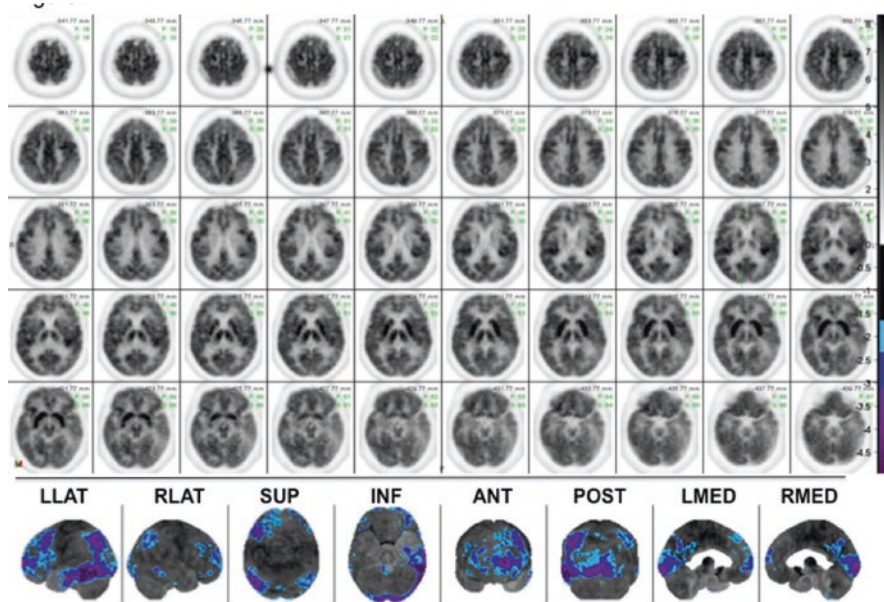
FDG PET scan showing serial axial images and surface-rendered z-score maps of significant hypometabolism relative to a normal control database showing selective mesial occipital hypometabolism in a patient with DLB. Additional temporoparietal and mild frontal association cortical hypometabolism is typical both of DLB and of AD
